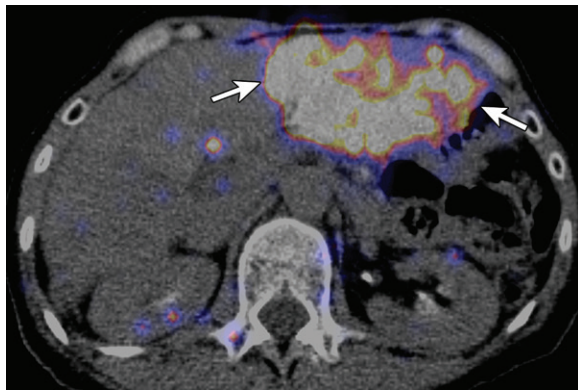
Assessment of technical success after ^{90}Y -sphere embolization in the same patient as in Figure 3. ^{90}Y PET/CT image obtained immediately after split ^{90}Y infusion in liver segments II and III shows homogeneous radiopharmaceutical uptake in the targeted tumor (arrows) and a lack of extrahepatic uptake.
